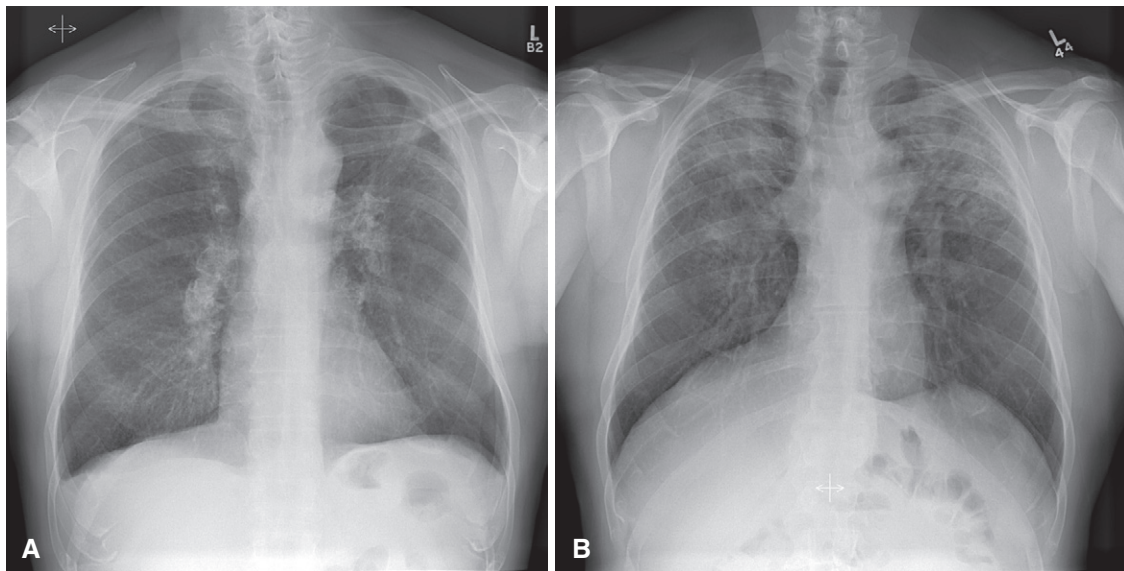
Posteroanterior chest radiographs from two patients with silicosis. A, Small nodules and eggshell calcification of hilar lymph nodes. B, Progressive massive fibrosis of the upper lung zones with compensatory emphysema.
